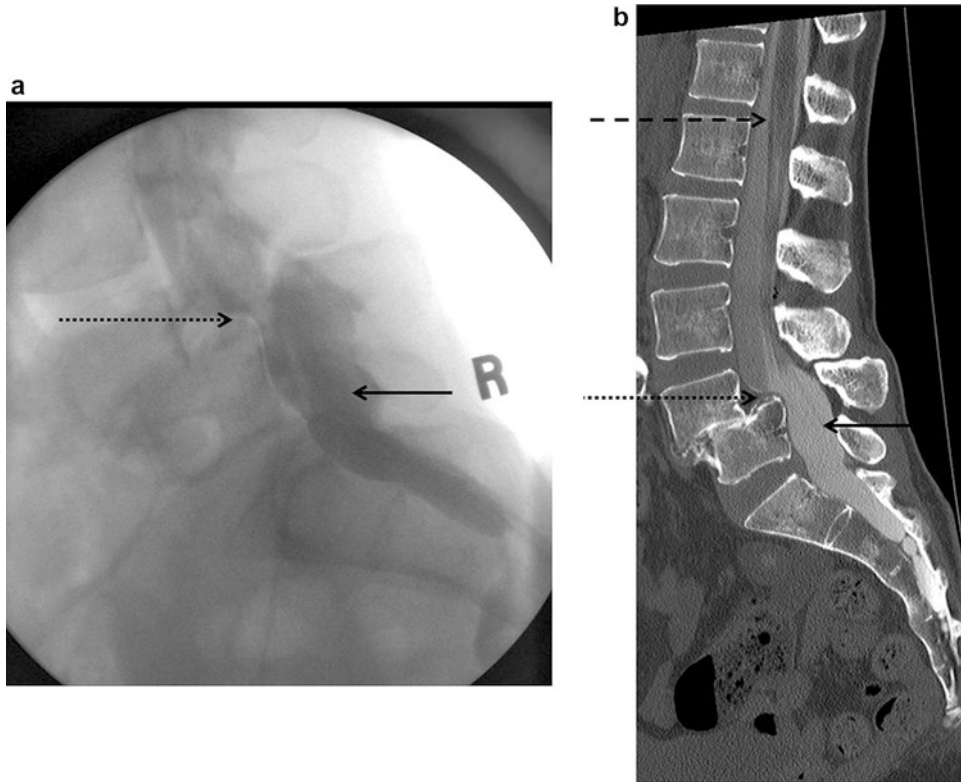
(a) Fluoroscopic images obtained during a myelogram shows contrast opacification of the thecal sac (*solid black arrow*) and ventral indentation from a disc-osteophyte complex (*dotted black arrow*) from marked intervertebral disc space narrowing and anterolisthesis (anterior spondylolisthesis) at the L4–L5 level. (b) Post-myelography, sagittal reformatted CT images of the lumbar spine shows again contrast opacification of the thecal sac
